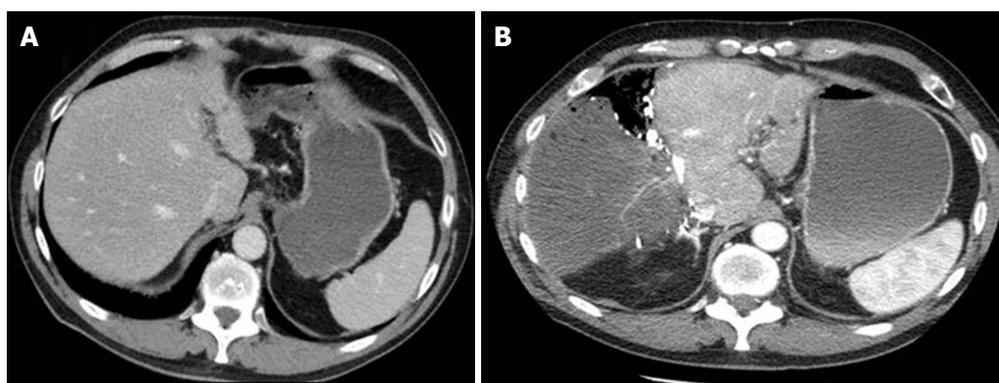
Pre-operative computed tomography (A) and on post-operative day 3 (B) following stage I of the associating liver partition and portal vein ligation for staged hepatectomy procedure.
